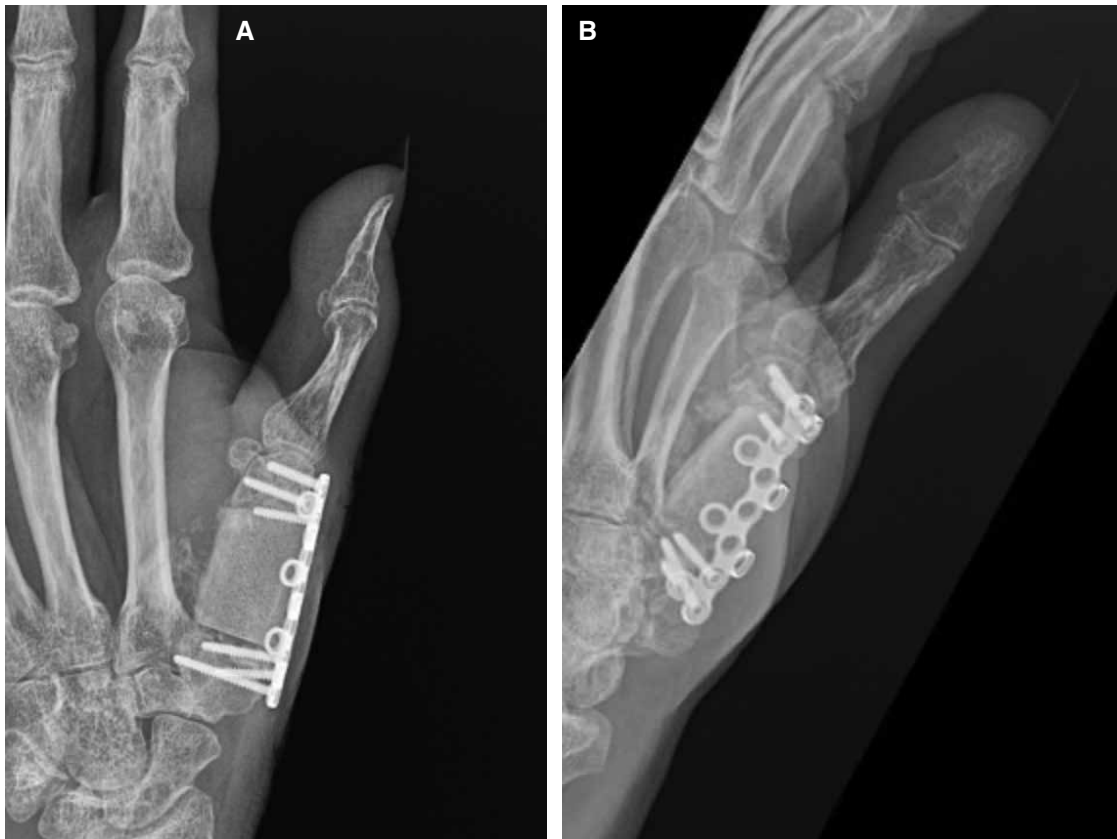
(A–B) Follow-up radiographs, two months s/p reconstruction.
